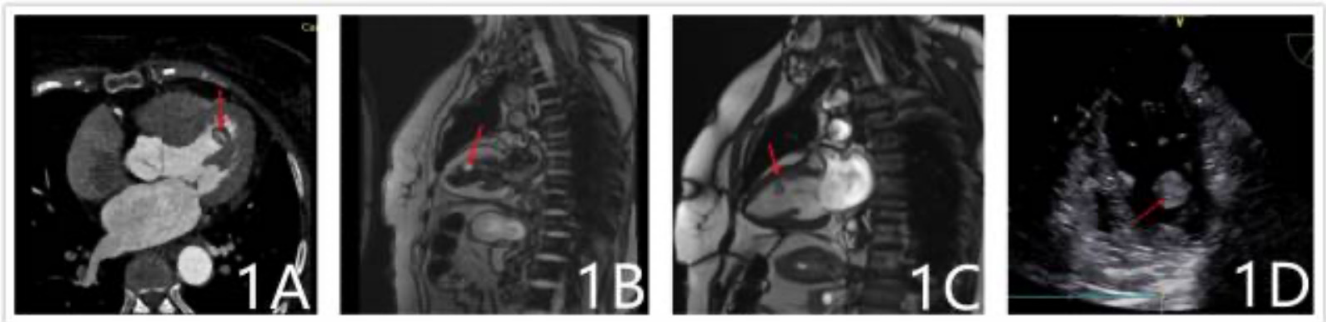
Imageology. A) Coronary computed tomography angiography demonstrated the mass was hypointense (diameter 1.5x1.2 mm), and a hyperintense vascular shadow can be seen; B) Cardiac magnetic resonance imaging demonstrating it was hyperintense on T1 sequences; C) Hypointense on T2 sequences; D) Transesophageal echocardiography reveals strong echo masses in the left ventricle and moderate mitral regurgitation.
